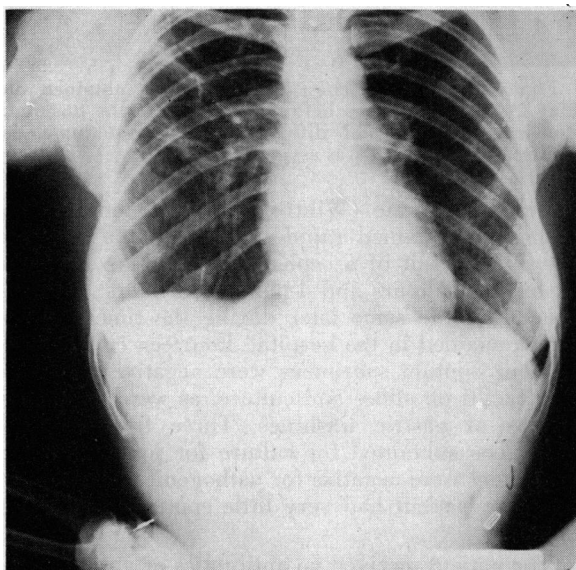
Chest roentgenogram taken November 9, 1960, six months following the film shown in Figure 4. Note the dramatic clearing of the granulomatous infiltrates which took place between 12 and 18 months after the patient discontinued the use of body spray.
